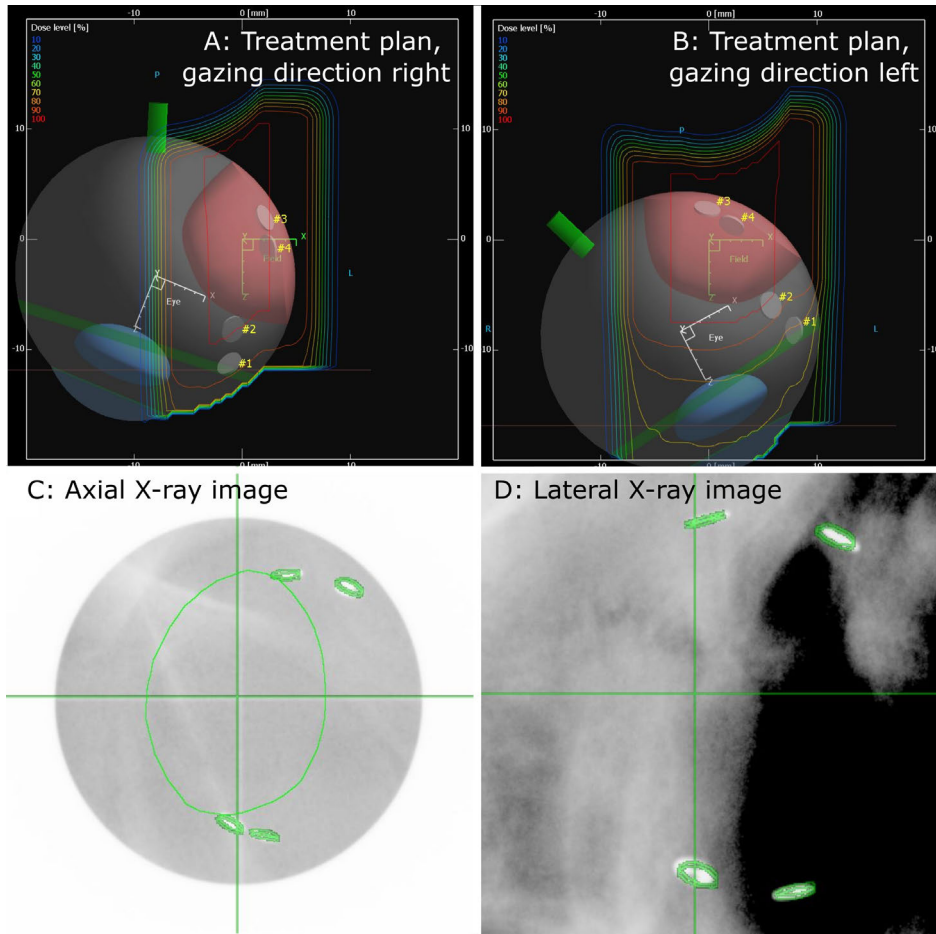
Treatment planning and resulting DRR. (A) An example of a treatment plan with gazing direction right (polar angle 25 degrees), sparing the anterior chamber. (B) Example of a treatment plan with gazing direction left (polar angle 25 degrees), lowering the macula dose but with a higher dose on the anterior chamber. (C, D) X-ray images (axial and lateral) taken during patient positioning with overlay of the aperture shape and clips (green lines).
